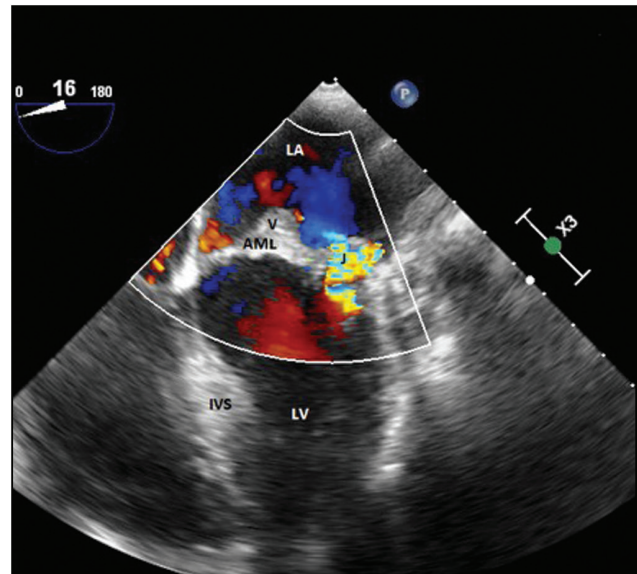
Four chamber view of transesophageal view showing mitral regurgitation jet and vegetation. AML = anterior mitral leaflet, IVS = interventricular septum, J = mitral regurgitation jet, LA = left atrium, LV = left ventricle, V = vegetation
